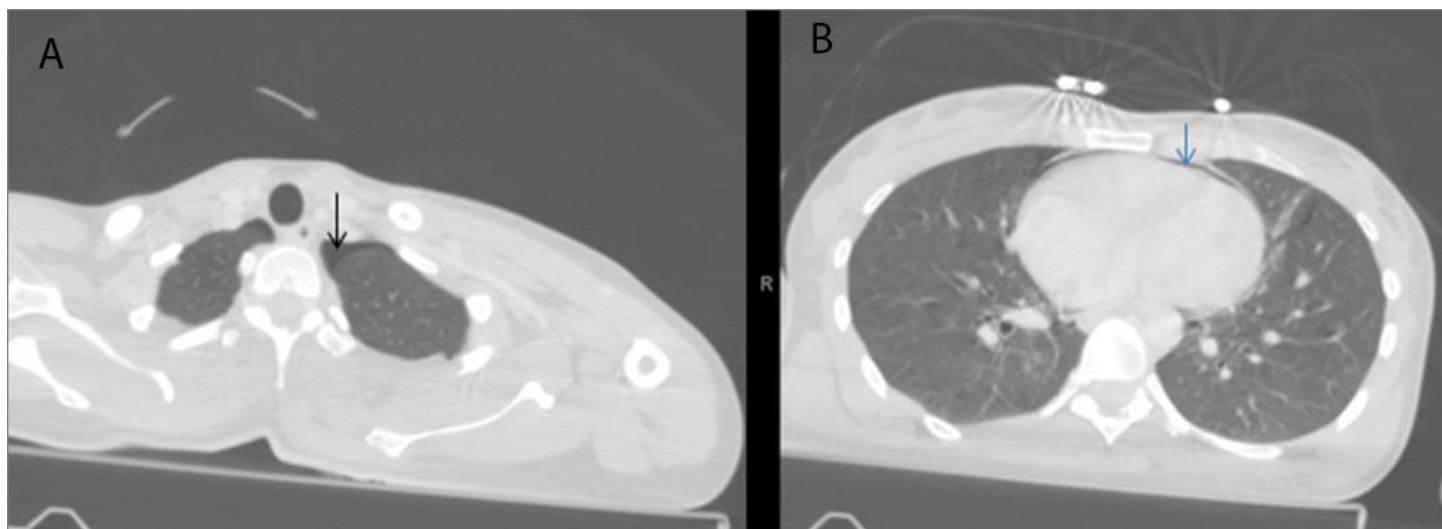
Thoraco-abdominal computed tomography showing pneumothorax, A, and pneumopericardium, B.
